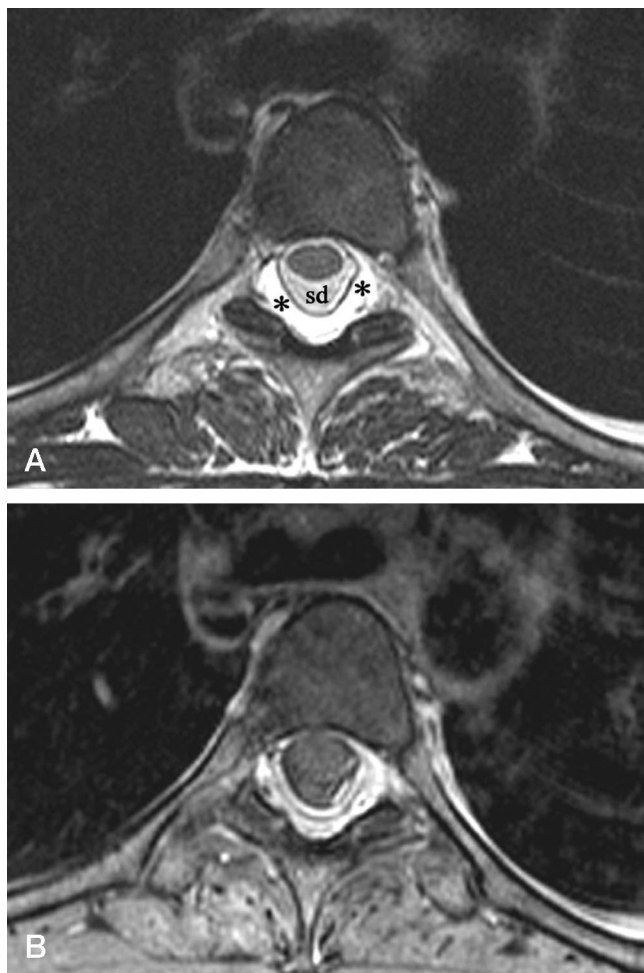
A, Axial T2-weighted MR image at the level of the seventh thoracic spine shows epidural (asterisks) and subdural fluid collection (sd). B, Contrast-enhanced fat-saturated axial T1-weighted MR image at the same level reveals diffuse enhancement in the spinal canal due to dural enhancement and engorged venous plexus.
